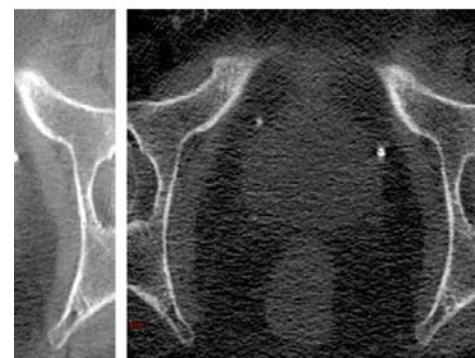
Calcifications shown on (A) planar computed tomography (CT) scan, (B) cone-beam CT scan with grid overlay.
